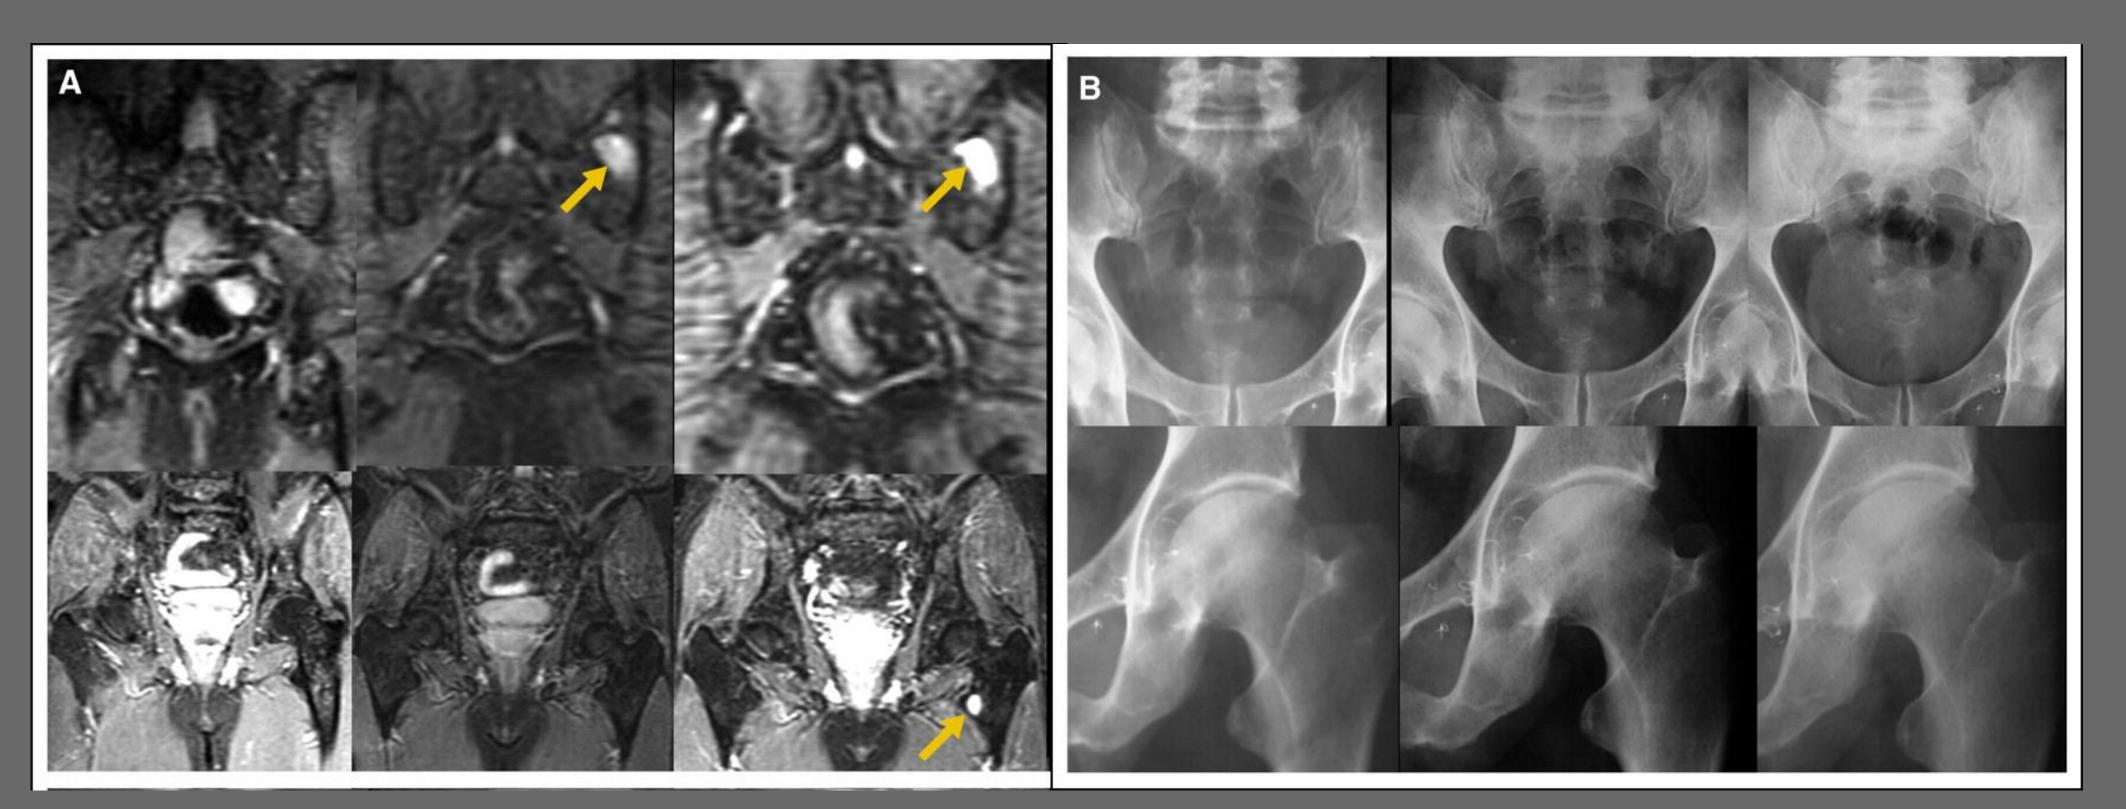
"Baseline short T1 inversion recovery magnetic resonance image (MRI) coronal views of pelvis show no focal lesions (FL). Over time, the patient develops a left sacral lesion and a lesion of the left lesser trochanter (A, arrows). X-rays of (B, top panel) the pelvis and (B, bottom panel) the proximal left femur at comparable time frames fail to demonstrate the FL seen on MRI."5
